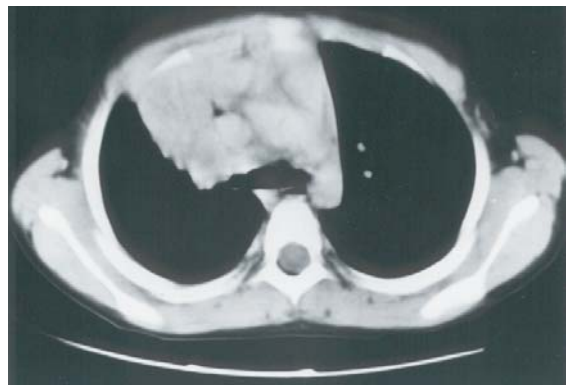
Chest computerized tomography (CT) scan, mediastinal window following two months of antituberculous treatment.
